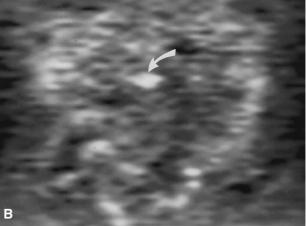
This patient with an elevated CA 19-9 level of 116 U/mL had undergone a Whipple procedure 10 months before the CT and PET studies shown here. A Axial contrast-enhanced abdominal CT shows abnormal heterogeneous soft tissue (*arrow*) in the surgical bed at the level of splenic venous confluence to the portal vein. Post-therapy changes cannot be distinguished from recurrent tumor. Low-attenuation region in the right hepatic lobe corresponds to a cyst. B The coronal
